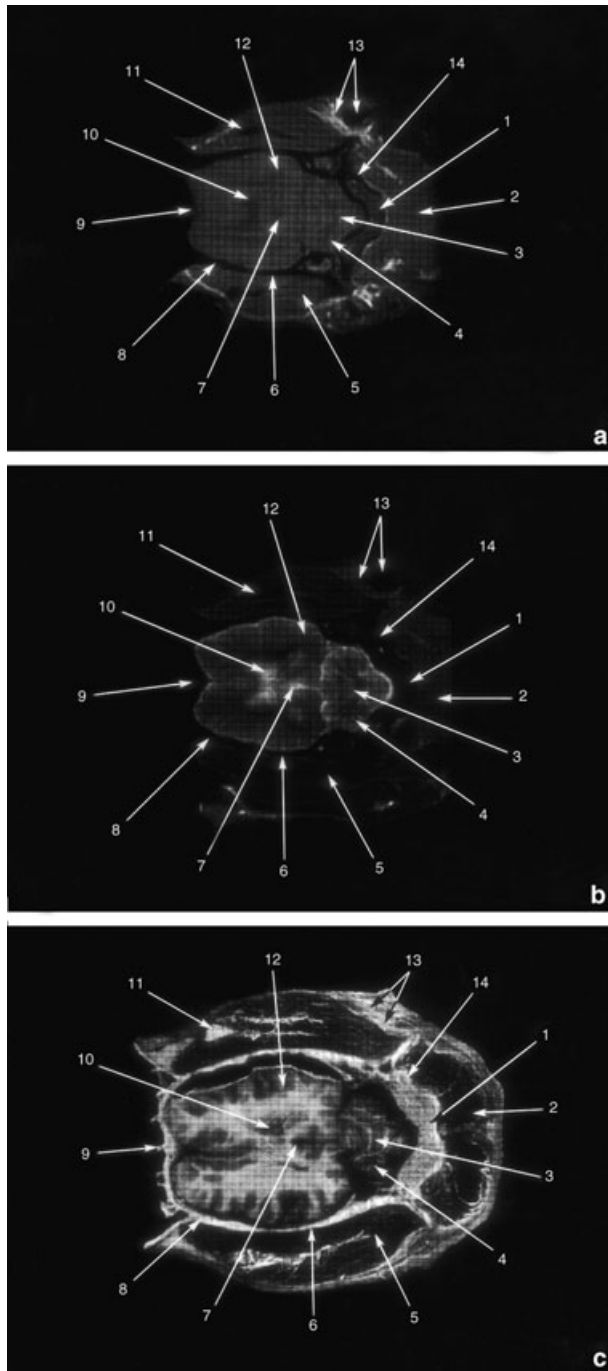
(a) T1-weighted oblique dorsal MR image, (b) T2-weighted oblique dorsal MR image, and (c) gross section at the level of frontal squama. 1, Occipital squama; 2, neck dorsal muscles; 3, cerebellar vermis; 4, cerebellar hemisphere; 5, temporal muscle; 6, squamous part of temporal bone; 7, third ventricle; 8, parietal bone; 9, frontal squama and frontal sinus; 10, lateral ventricle; 11, coronoid process of ramus of mandible; 12, cerebral hemisphere: cerebral cortex; 13, auricle and auricular fat; 14, nuchal crest.
